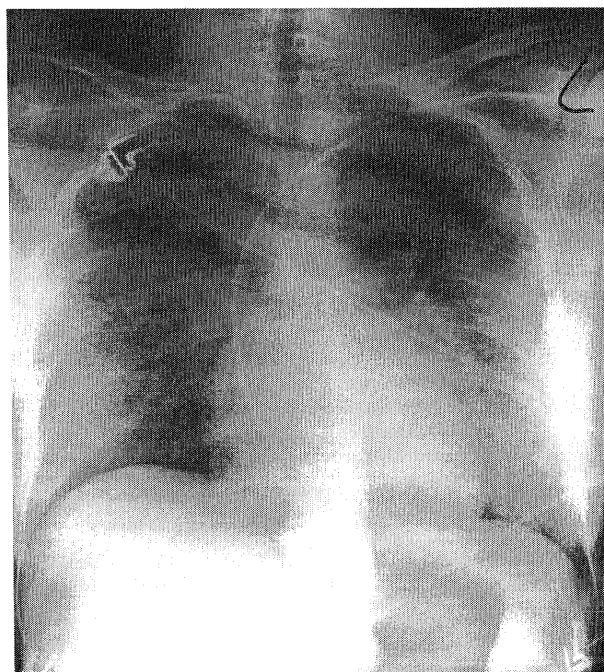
Chest radiograph showing diffuse bilateral alveolar infiltrates in a patient with acute respiratory failure associated with indinavir therapy (the radiograph was obtained while the patient was supine).
